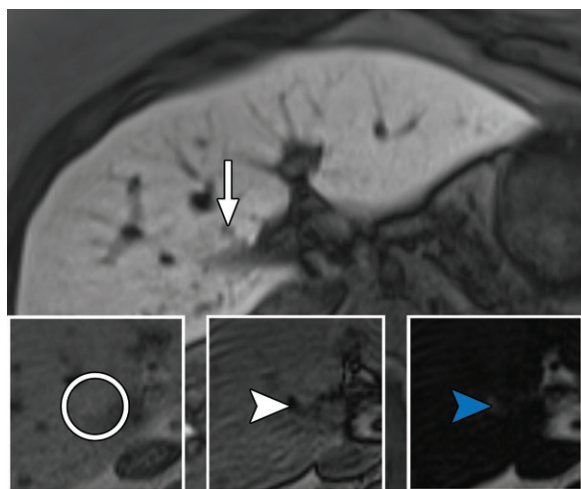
Focal hepatic steatosis mimicking hepatic metastasis in a 63-year-old woman with metastatic leiomyosarcoma. Axial T1-weighted HBP MR image shows a hypointense lesion (arrow) corresponding to the finding at CT that prompted MRI. In-phase (left inset) and opposed-phase (middle inset) chemical shift MR images show focal hypointensity (white arrowhead) at opposed-phase imaging compared with that at in-phase imaging (circle), consistent with focal fat. Fat-only Dixon image (right inset) shows corresponding hyperintensity (blue arrowhead). Dixon imaging is a useful additional technique for depicting steatosis.
